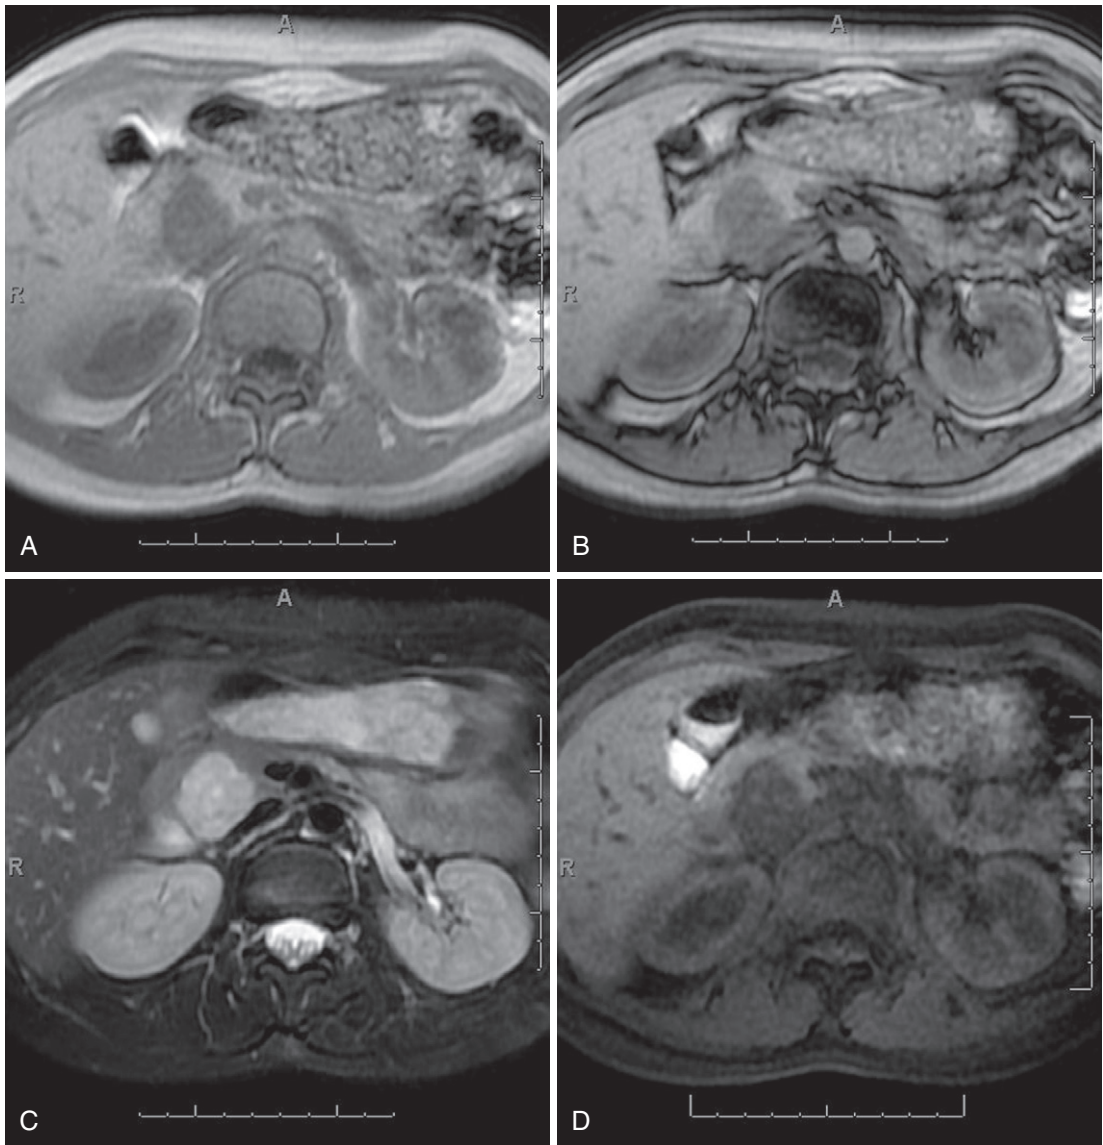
Solid-cystic papillary epithelial neoplasm (SPEN). In-phase (A) and out-of-phase (B) T1-weighted gradient recalled-echo, fat-suppressed T2-weighted (C), and fat-suppressed T1-weighted gradient recalled-echo (D) images demonstrate a decreased T1-weighted signal intensity, increased T2-weighted signal intensity mass, without upstream pancreatic duct dilatation, within the head of the pancreas in this young female African American patient. Noncontrast (E), early arterial (F), late arterial (G), and delayed (H) CT images demonstrate calcification and mild delayed enhancement of the same mass. These findings are characteristic of SPEN of the pancreas, which was confirmed at surgery.
